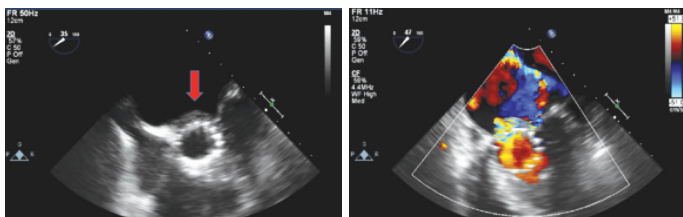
Echocardiography at 25th day.
